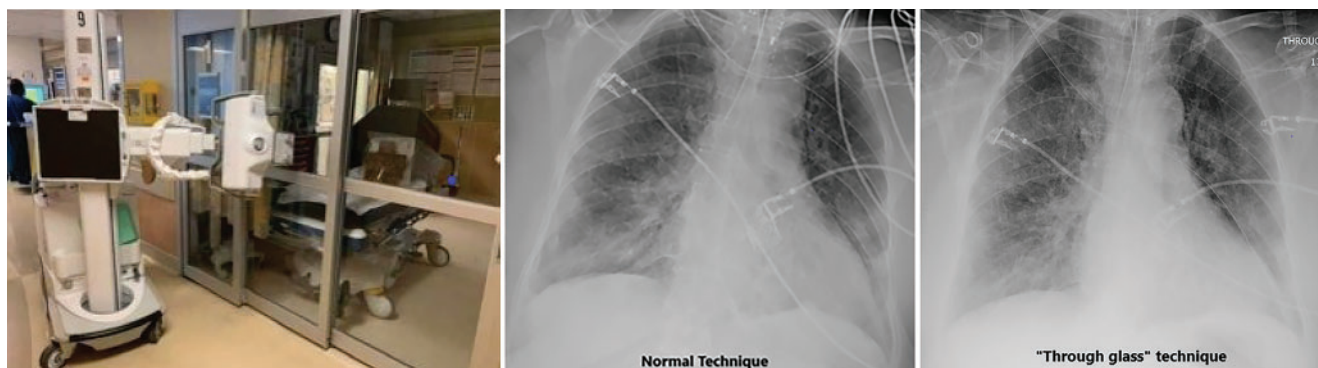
(Left) Setup for obtaining chest radiographs through the glass wall of the room of a patient with suspected or confirmed COVID-19. (Middle) A radiograph obtained in the conventional manner. (Right) A radiograph obtained through the glass.
